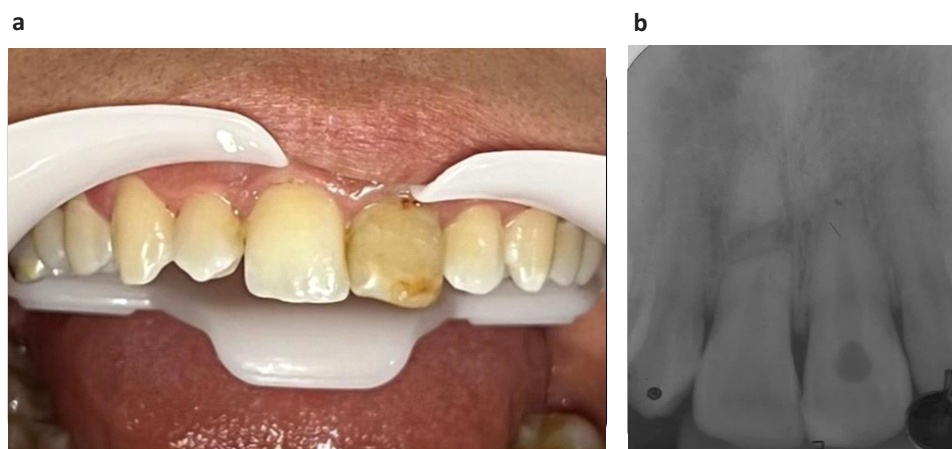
a) Initial clinical photograph showing the esthetic appearance of the maxillary incisors, with slight discoloration of the affected tooth. b) Initial periapical radiograph demonstrating a radiolucent line consistent with horizontal root fracture.
